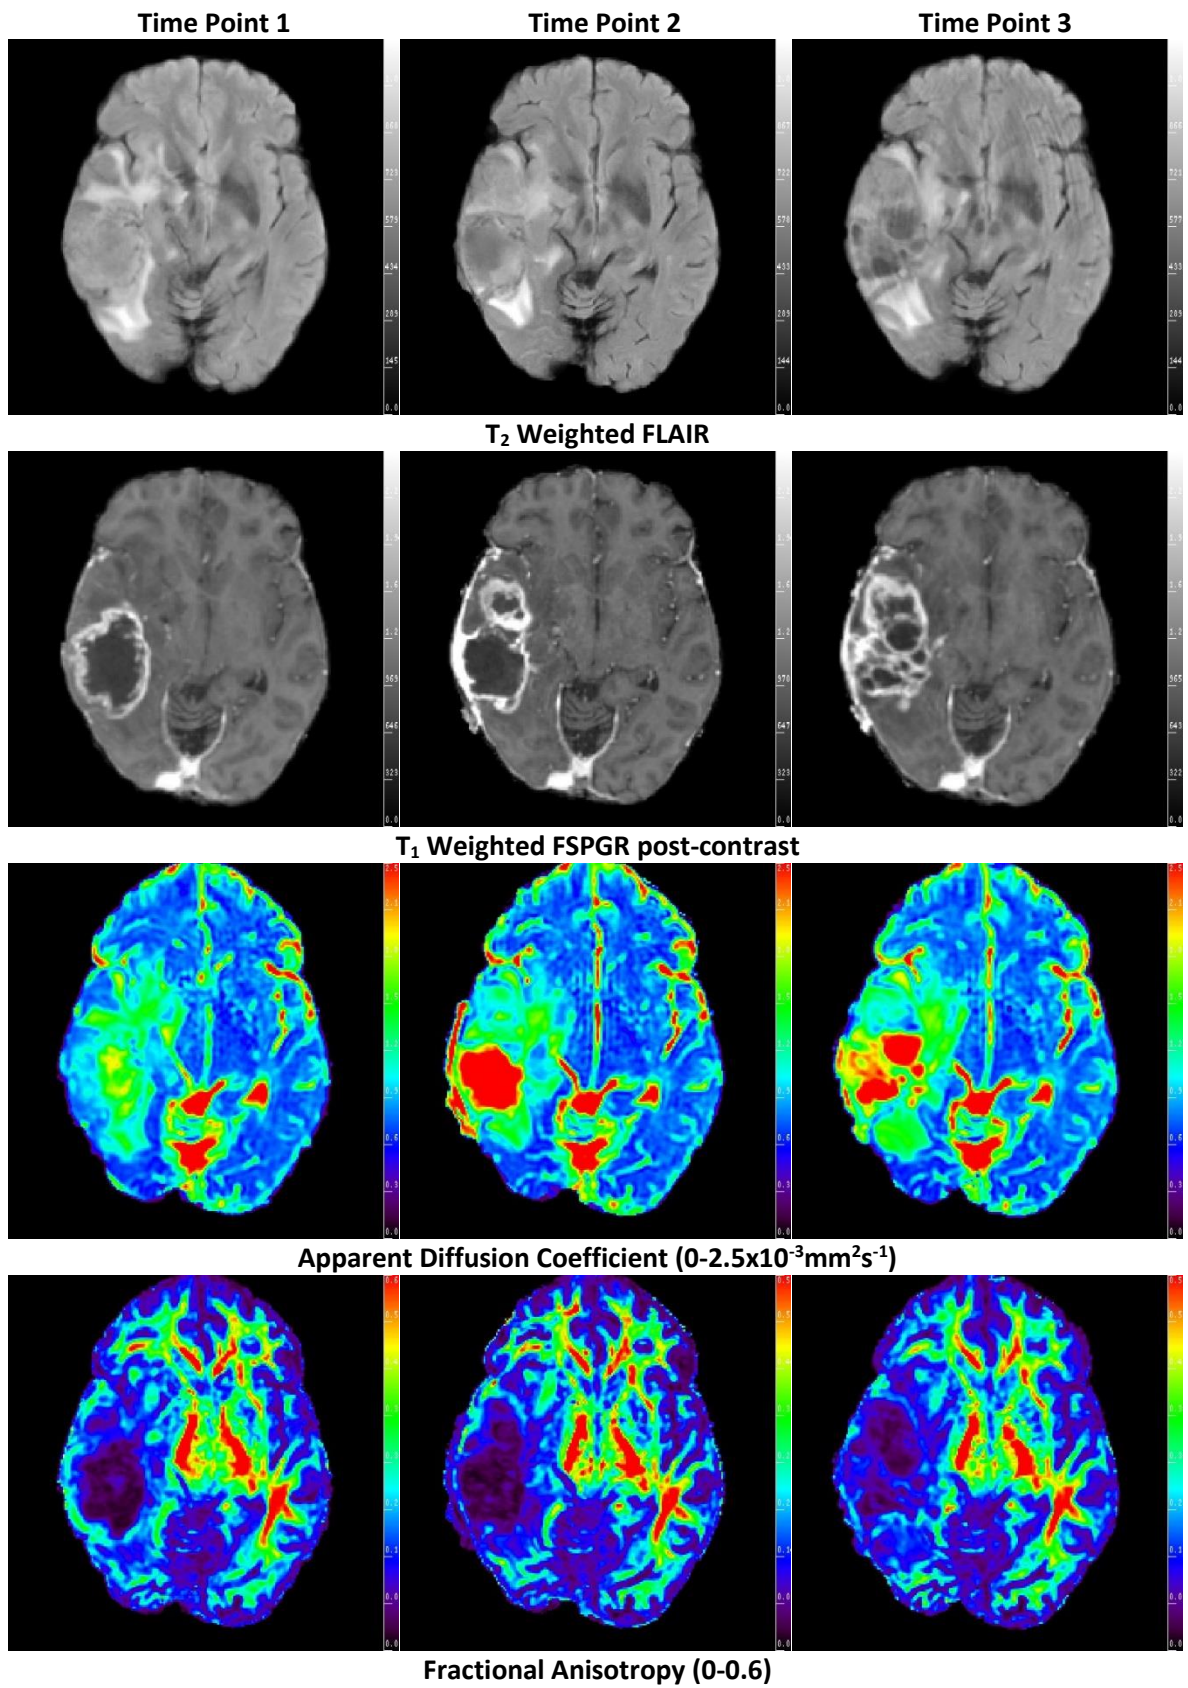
Example slice from the 4D volume showing all 15 parameters spatially registered ready for temporal registration or sampling. From top left to bottom right:  $T_2$  FLAIR,  $T_1$  post contrast, ADC ( $0-2.5 \times 10^{-3} \text{mm}^2 \text{s}^{-1}$ ), FA ( $0-0.6$ ),  $q$  ( $0-0.85 \times 10^{-3} \text{mm}^2 \text{s}^{-1}$ ), RA ( $0-0.6$ ),  $\lambda_L$  ( $0-3 \times 10^{-3} \text{mm}^2 \text{s}^{-1}$ ),  $\lambda_R$  ( $0-3 \times 10^{-3} \text{mm}^2 \text{s}^{-1}$ ),  $R_1$  ( $0-2 \text{s}^{-1}$ ),  $K^{\text{trans}}$  ( $0-0.2 \text{min}^{-1}$ ),  $v_e$  ( $0-0.75$ ),  $v_b$  ( $0-0.15$ ),  $rCBV_{\text{GVF}}$  ( $0-7.5$ ),  $rCBV_{\text{BOX}}$  ( $0-7.5$ ), and  $K_2$  ( $-3.3-0.7$ ).
